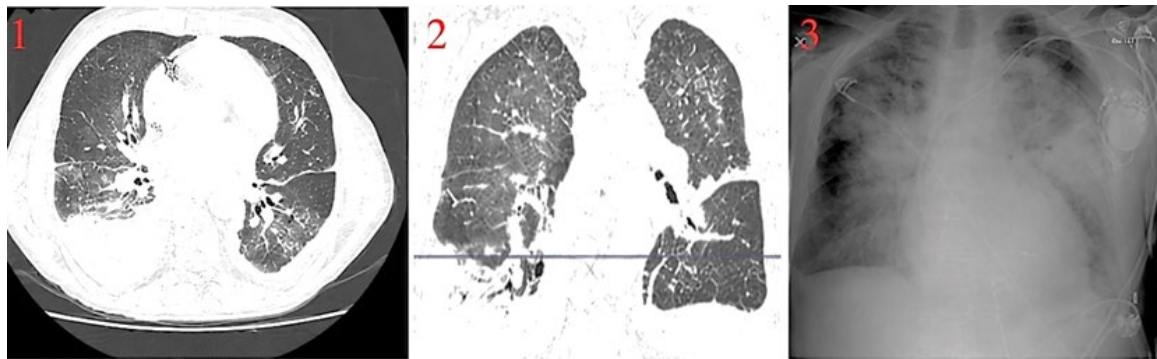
Thoracic imaging findings. (1, 2) Axial and coronal views of non-contrast chest computed tomography showing bilateral pleural effusions and diffuse alveolar-interstitial infiltrates, initially interpreted as pulmonary edema. 3) Chest radiograph showing diffuse bilateral alveolar infiltrates with a butterfly-wing appearance and an enlarged cardiac silhouette, suggestive of pulmonary edema at a subsequent admission.
